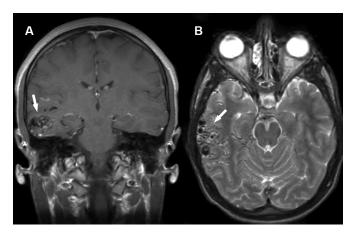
Magnetic resonance imaging (coronal [left] and axial [right] views) showing the arteriovenous malformation (white arrow).
